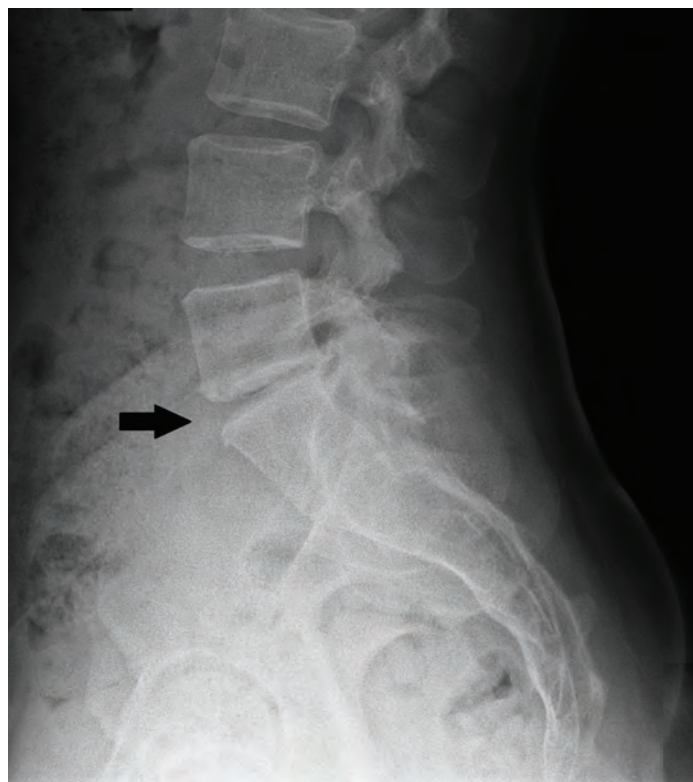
Lateral view of the pre-operative x-ray: the arrow identifies the L5/S1 disc with loss of disc height and bone spur formation.
